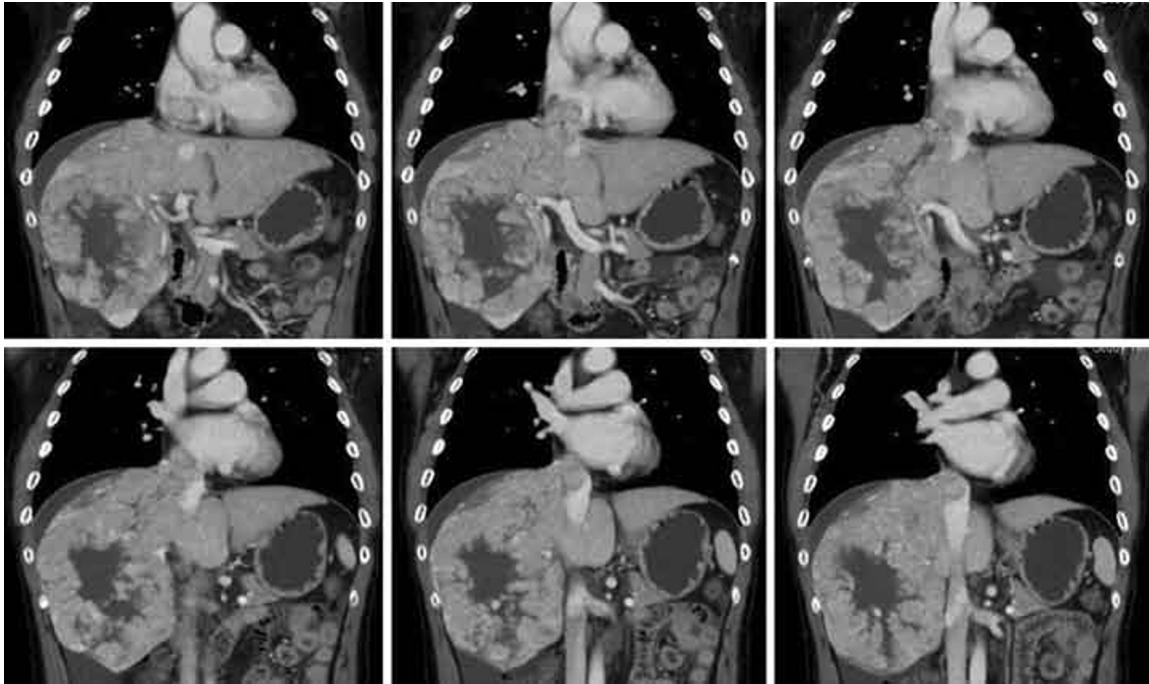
Sagittal CT showing right lobe HCC with invasion into the IVC and RA.
